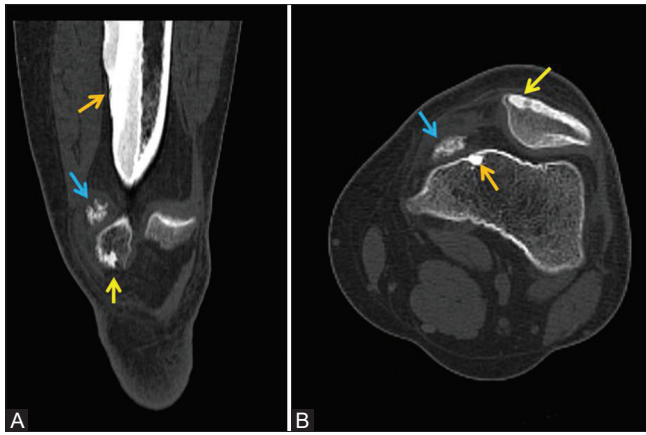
(A and B): Coronal (A) and Axial (B) CT showing ossification along medial femoral cortex (orange arrow), small calcified lesion along medial patellar retinaculum with adjacent fat stranding and edema (blue arrow) and ossific foci along medial aspect of patella (yellow arrow)
